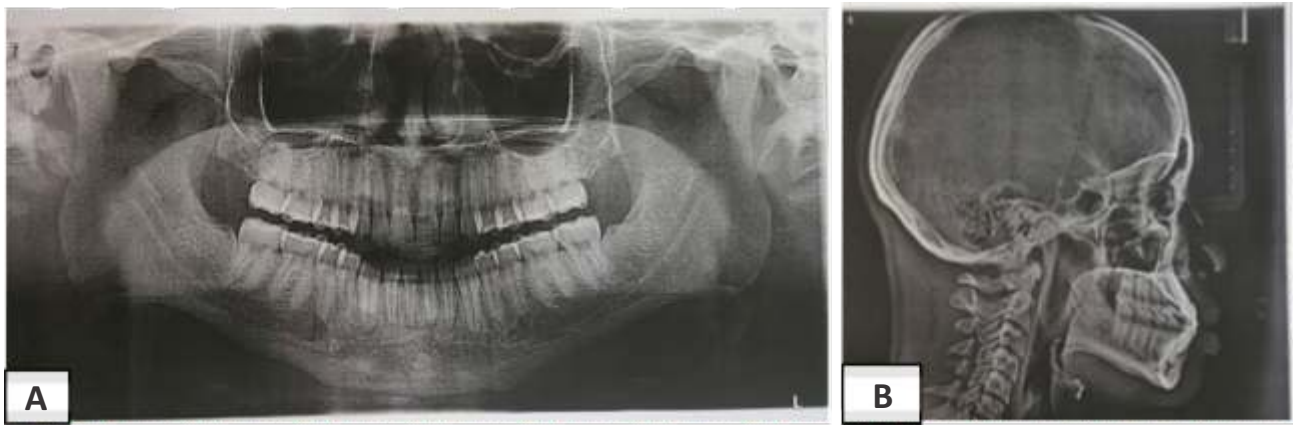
(A) Pretreatment panoramic radiograph, and (B) Pretreatment lateral cephalograph
